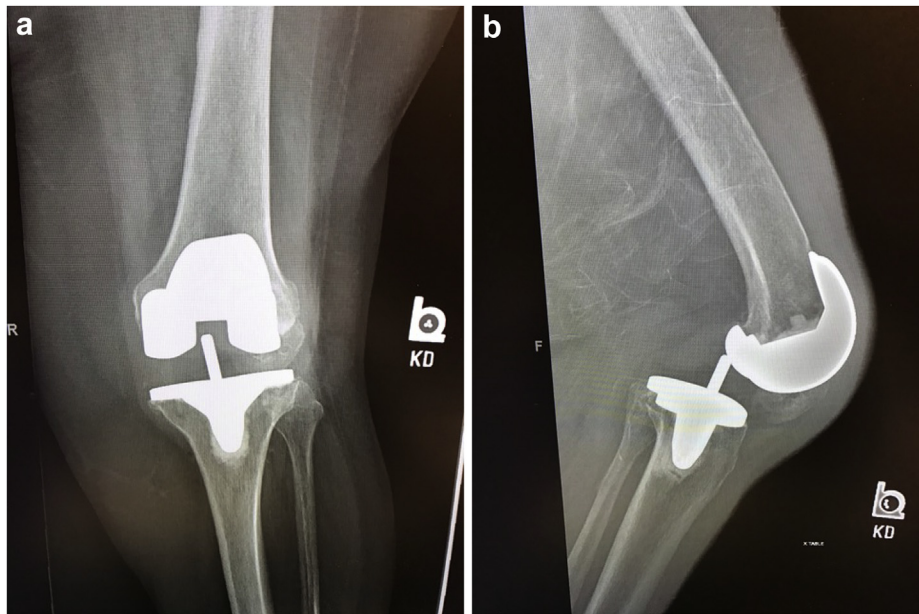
AP (a) and lateral (b) radiographs demonstrating a cemented left total knee arthroplasty posterior-stabilized rotating platform device, with both posterior and patellar dislocation.
